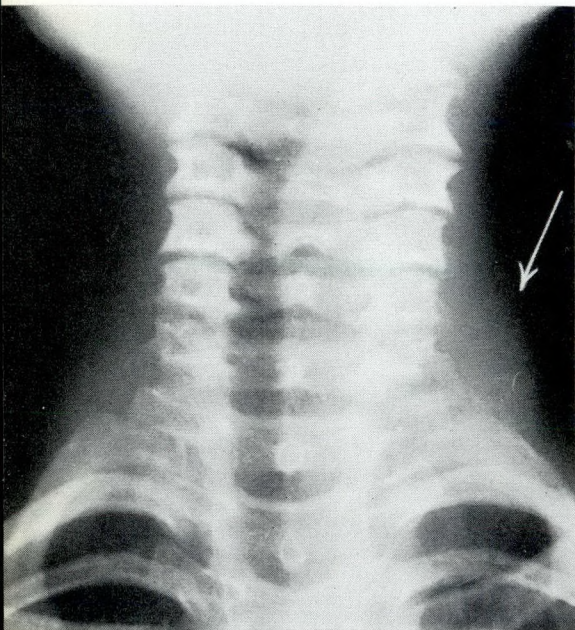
Case 4. Radiograph of the neck showing the soft tissue mass on the left with displacement of the trachea to the right.
